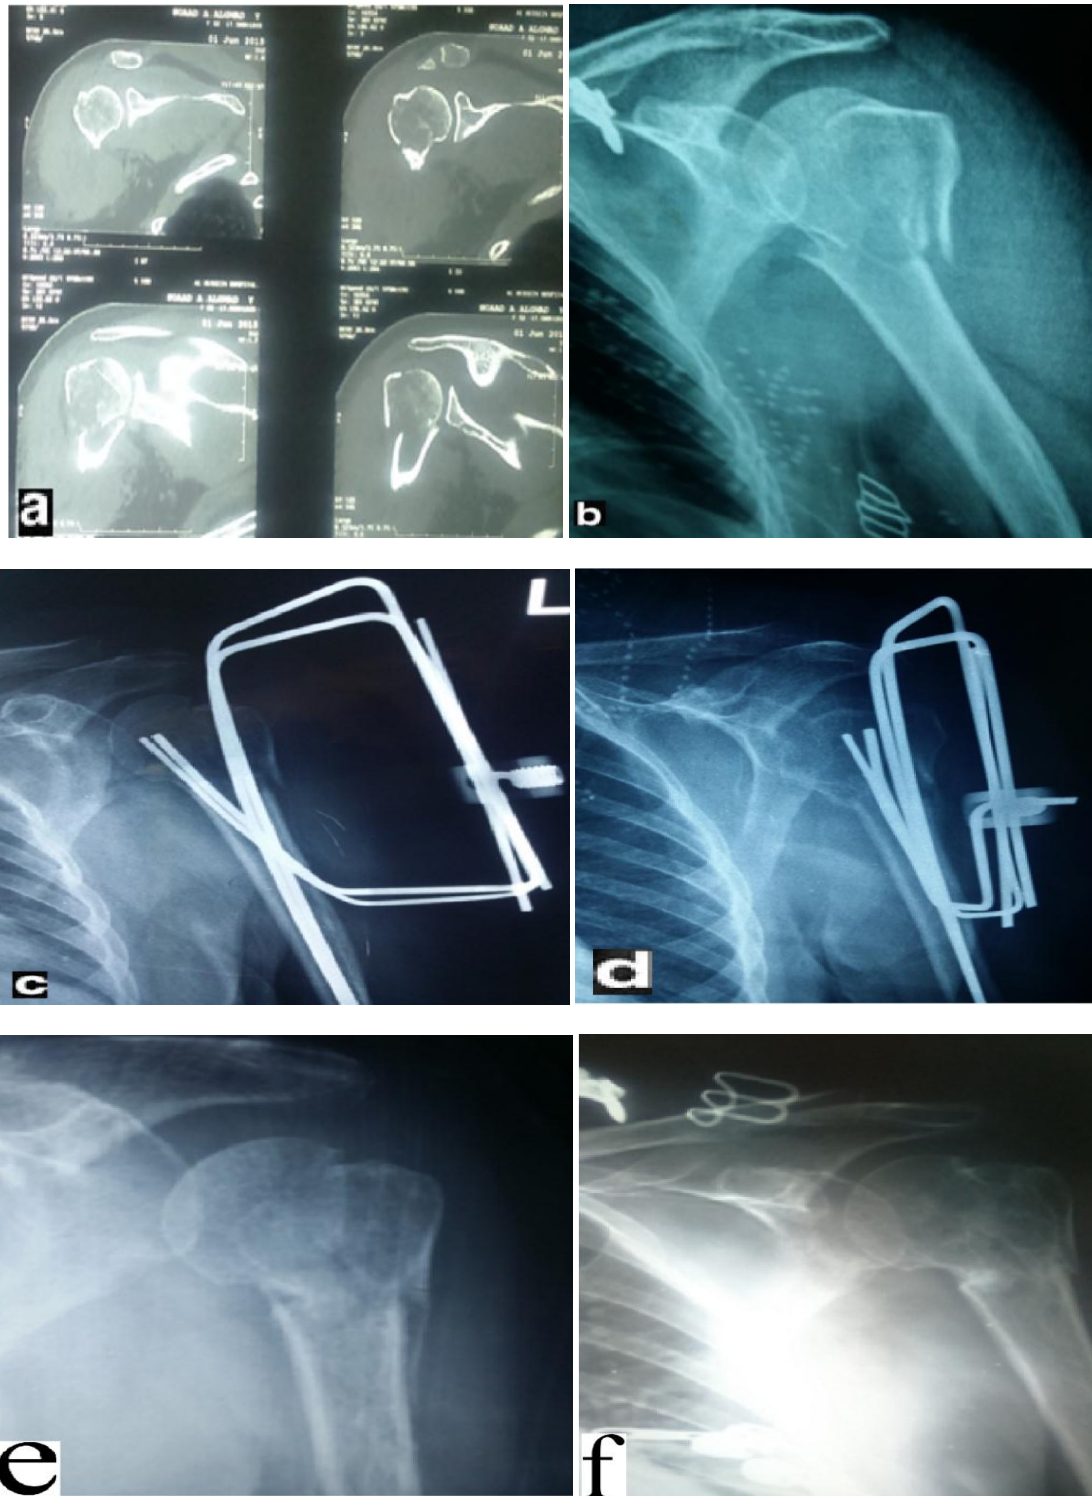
Female patient 68 years old with LT. 3-parts fracture proximal humerus,(a) preoperative CT scan,(b) preoperative X ray AP view,(c) 6 weeks follow up,(d) 2 months follow up,(e) 6 months follow up after removal,(f) 12 months follow up after removal.
